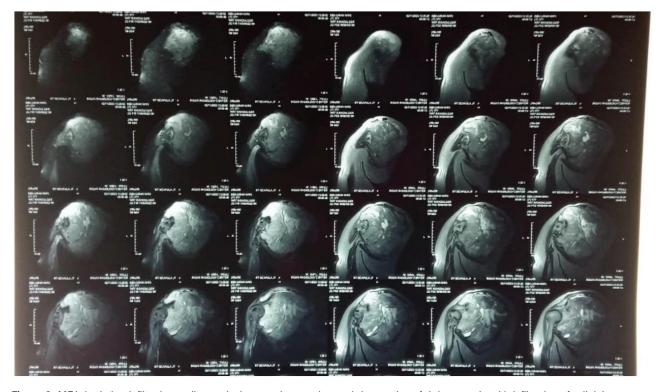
MRI depicting infiltrative malignant lesion causing erosion and destruction of right scapula with infiltration of adjoining muscles.
